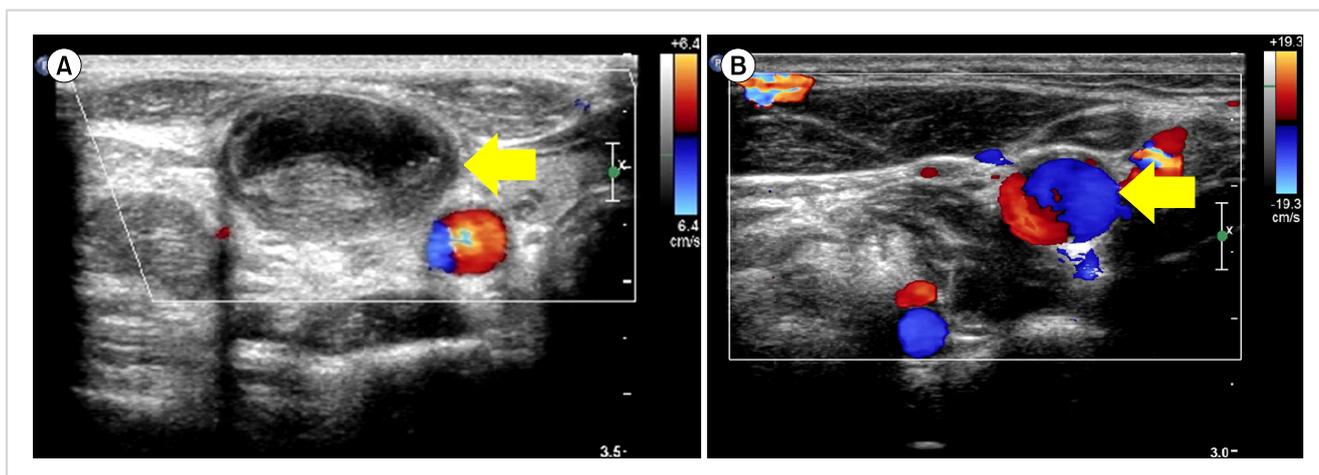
Initial neck Doppler ultrasonography revealing an expansile thrombus in the right jugular vein (A, arrow). Three months after the completion of chemotherapy, the thrombus disappeared and the flow in the vein normalized (B, arrow).
